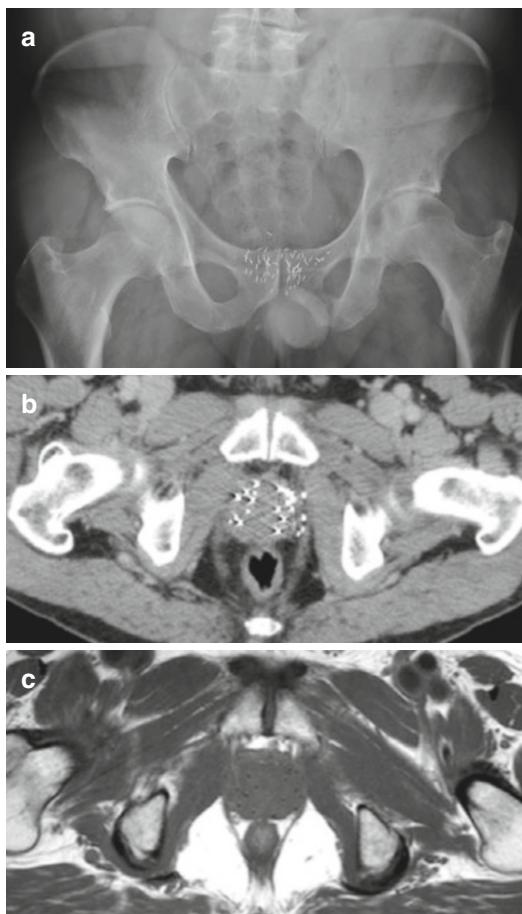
Brachytherapy seed position on imaging. (a) Pelvic radiograph showing the position and orientation of the brachytherapy seeds. (b) Axial CT and (c) axial T1-weighted images through the prostate show the position of the radioactive seeds. The seeds are seen as dense material on the CT and as signal voids on MR imaging
